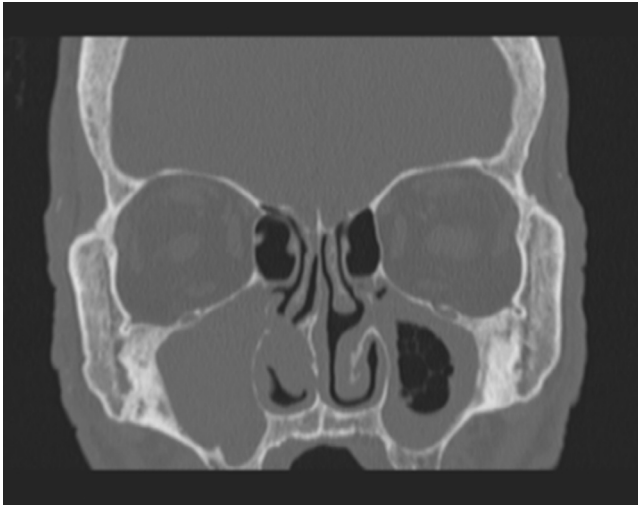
Computed tomography of coronal sinus in bone windows demonstrating mucosal thickening and frothy secretions in the left maxillary sinus with complete opacification of the right maxillary sinus consistent with acute on chronic rhinosinusitis during initial presentation with sinusitis symptoms after dental extraction.
